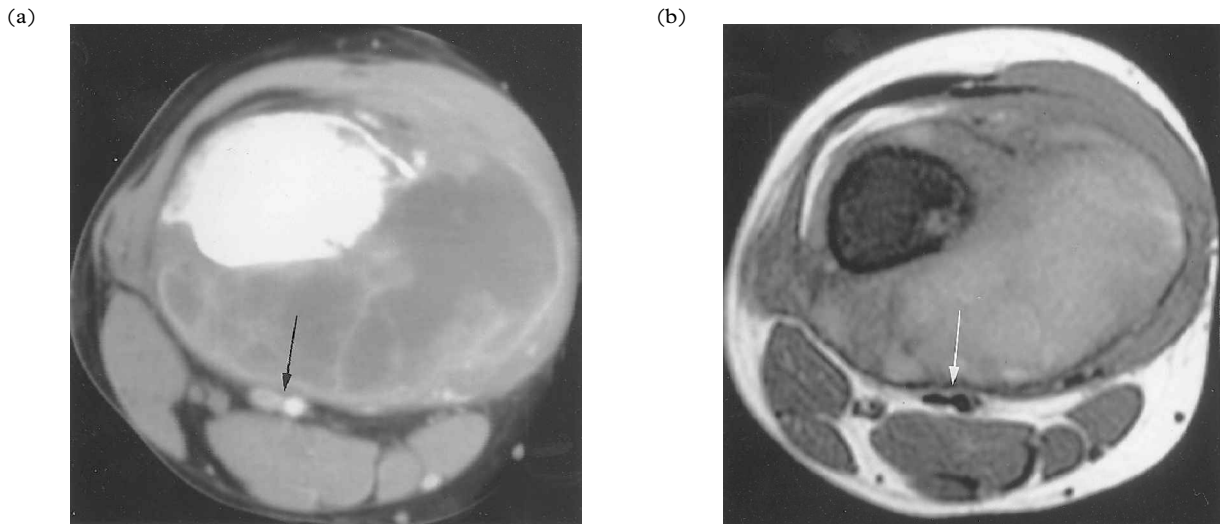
Vascular displacement, but no direct contact with tumor: (a) contrast-enhanced CT scan and (b) T1-weighted (600/12) MR image. The large soft tissue mass due to osteogenic sarcoma of the distal femur displaces the popliteal vessels posteriorly. The tissue plane visible between the vessels (arrow) and the margin of the mass indicates that no gross tumor involvement of the vessels has occurred.
